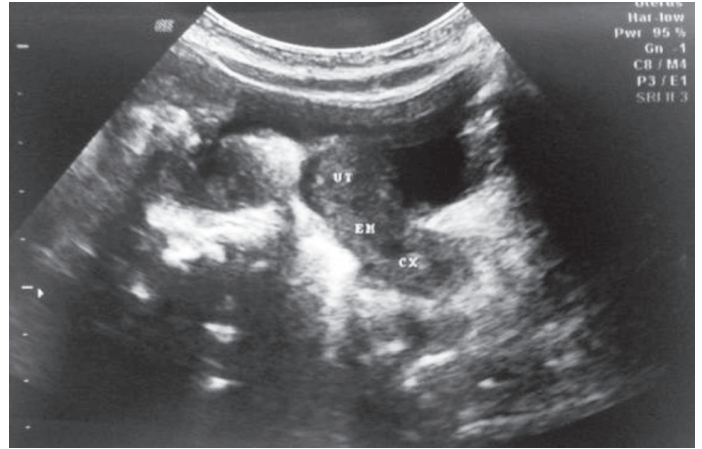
Pelvic ultrasound shows a normal sized for age, retroverted uterus and an intact hyperechoic endometrium.
